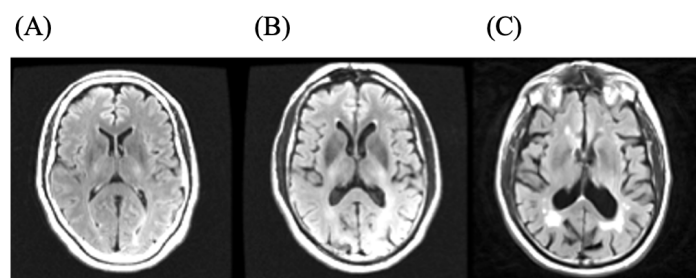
Brain changes assessed in (A) control (B) MCI and (C) AD patients by MRI [33].
